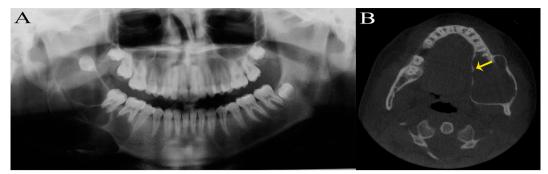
Ameloblastoma. (A) PR showing displacement of mandibular low border. (B) CT image displaying tongue-shape crest (arrow) and ballooning expansion associated with resorption of cortical bones.
